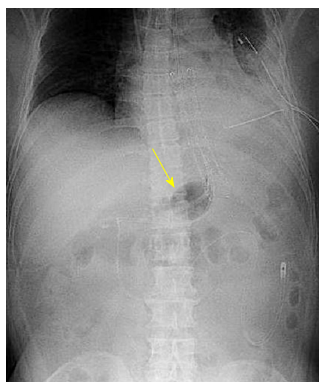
Abdominal radiograph. The SBT gastric balloon was inflated slightly larger than the stent diameter (arrow) to support the stent. The nasoesophageal feeding tube was positioned in the jejunum. SBT: Sengstaken-Blakemore tube.
